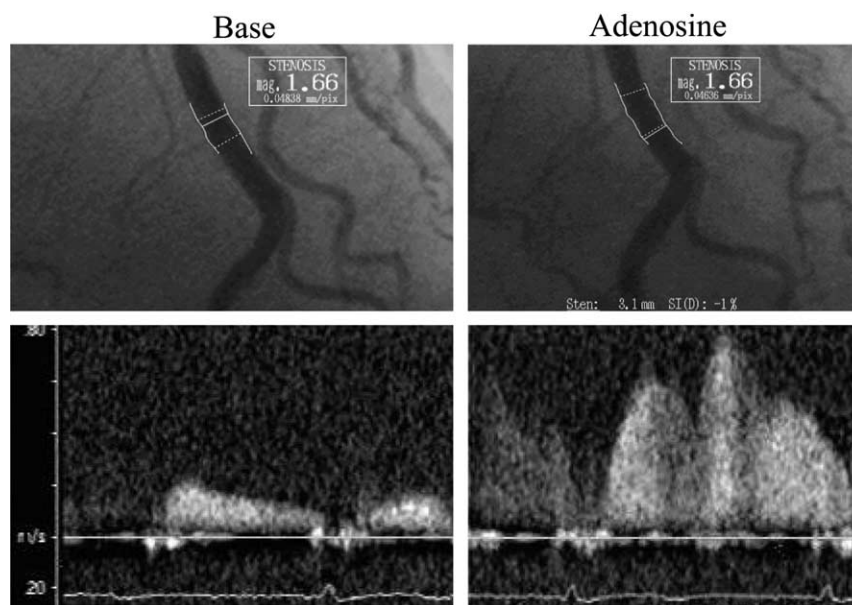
Adenosine is the drug of choice to measure coronary flow velocity reserve by Doppler, because it is a pure microvascular dilator and does not significantly alter the calliper of the epicardial coronary artery. Therefore, relative changes in velocity can be used as surrogate measures of flow.
